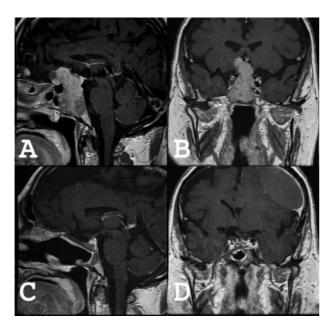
Preoperative (A) sagittal and (B) coronal magnetic resonance imaging (MRI) showing a large invasive pituitary macroadenoma. Postoperative (C) sagittal and (D) coronal MRI at 3 months showing gross total resection of the tumor and a large left frontal convexity subdural hematoma.
